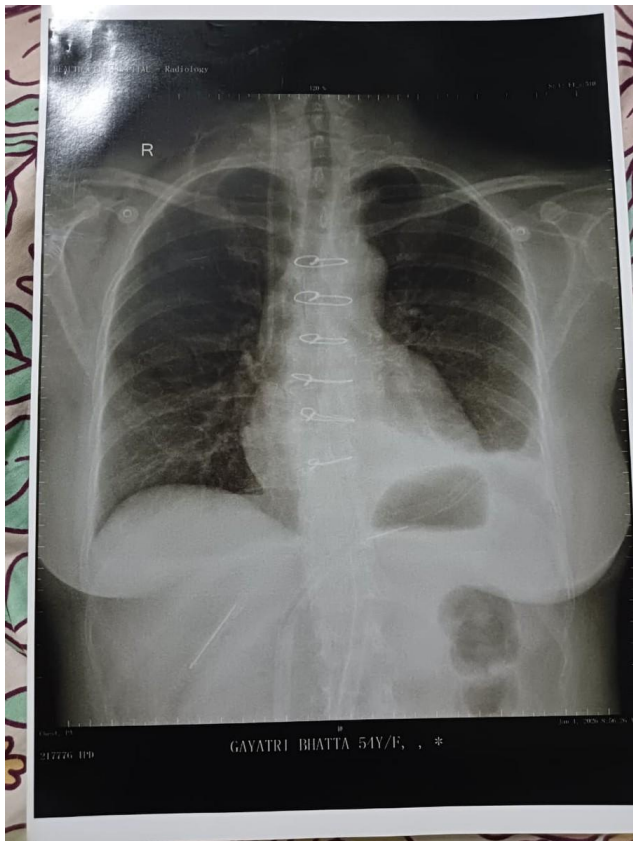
Post-operative chest X-ray (PA view) showing satisfactory cardiac silhouette, sternal wires, and resolution of the left cardiac border opacity
